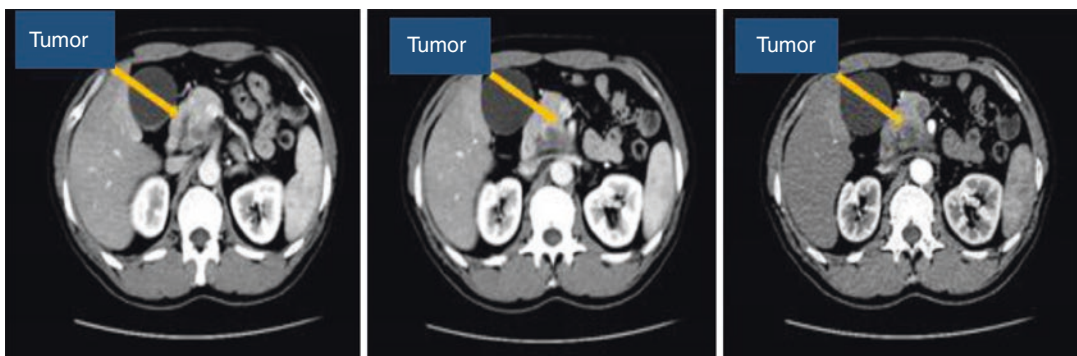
CT images show a mass in the pancreatic head
